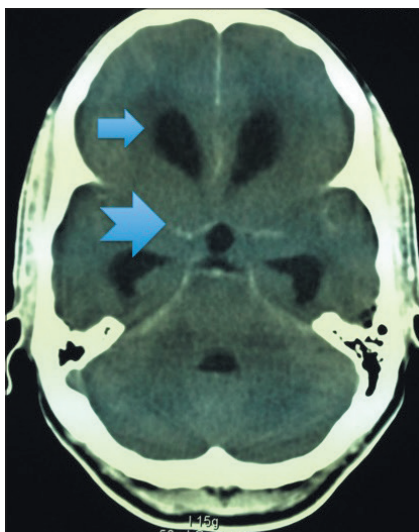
CT scan – patient with TBM. Note the emerged ventricles and some contrast enhancement around the circle of Willis. The contrast enhancement is often much brighter. The large arrow indicates large ventricles, the small notched arrow indicates contrast enhancement in the circle of Willis.
